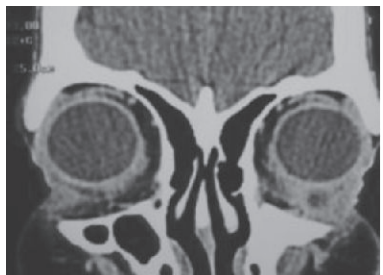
CT scan (coronal section) - diffuse contrast enhancing soft tissue thickening anterior to the orbital septum (left side)
